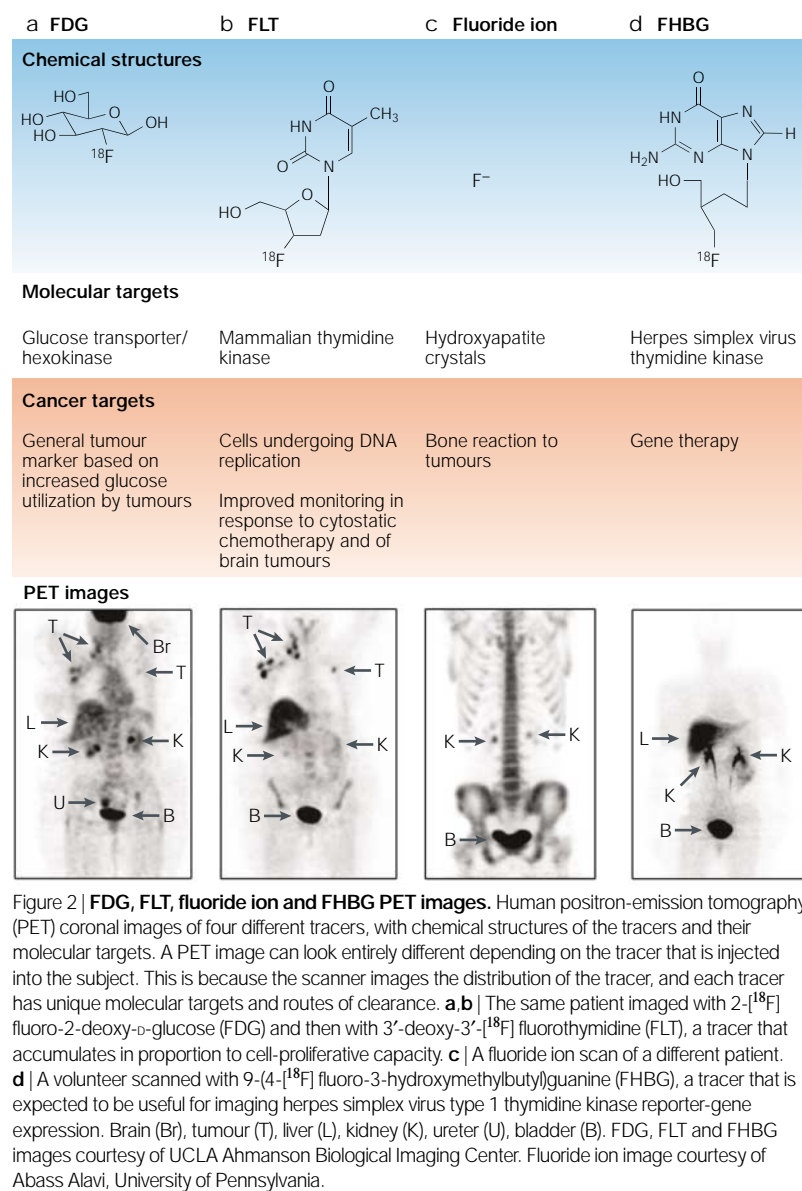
FDG, FLT, fluoride ion and FHBG PET images. Human positron-emission tomography (PET) coronal images of four different tracers, with chemical structures of the tracers and their molecular targets. A PET image can look entirely different depending on the tracer that is injected into the subject. This is because the scanner images the distribution of the tracer, and each tracer has unique molecular targets and routes of clearance. a, b | The same patient imaged with 2-[¹⁸F] fluoro-2-deoxy-D-glucose (FDG) and then with 3'-deoxy-3'-[¹⁸F] fluorothymidine (FLT), a tracer that accumulates in proportion to cell-proliferative capacity. c | A fluoride ion scan of a different patient. d | A volunteer scanned with 9-(4-[¹⁸F] fluoro-3-hydroxymethylbutyl)guanine (FHBG), a tracer that is expected to be useful for imaging herpes simplex virus type 1 thymidine kinase reporter-gene expression. Brain (Br), tumour (T), liver (L), kidney (K), ureter (U), bladder (B). FDG, FLT and FHBG images courtesy of UCLA Ahmanson Biological Imaging Center. Fluoride ion image courtesy of Abass Alavi, University of Pennsylvania.
